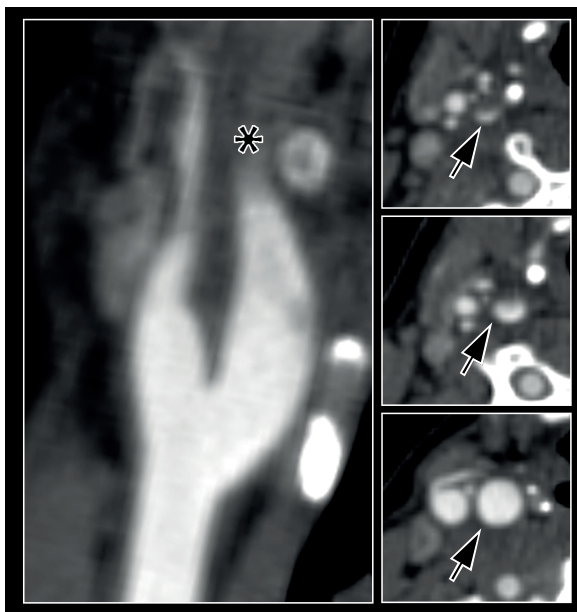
Computed tomography angiography of carotid artery dissection. Sagittal (asterisk) and axial (arrows) reconstructions show an eccentric narrowing of the true lumen (string sign) without involvement of the carotid bulb.
